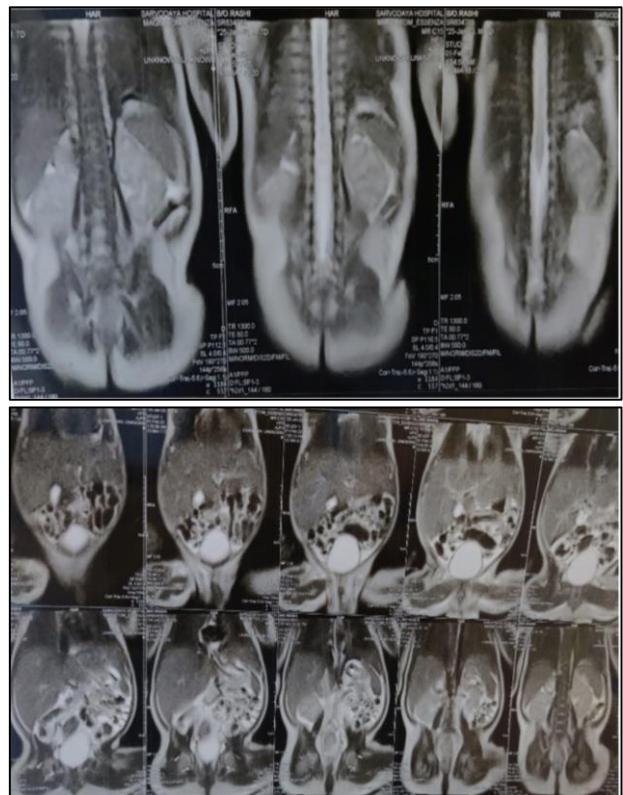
MRI abdomen revealed features of subacute right adrenal haemorrhage. Focal soft tissue lesion seen replacing the right adrenal gland of mixed signal intensity appearing hyperintense on T1/T2w images with surrounding T2 hypo intensity which shows blooming on GRE images suggesting subacute adrenal haemorrhage. It measures 1.4/1.7/2.3 cm. It is seen abutting the superior pole of the right kidney.
